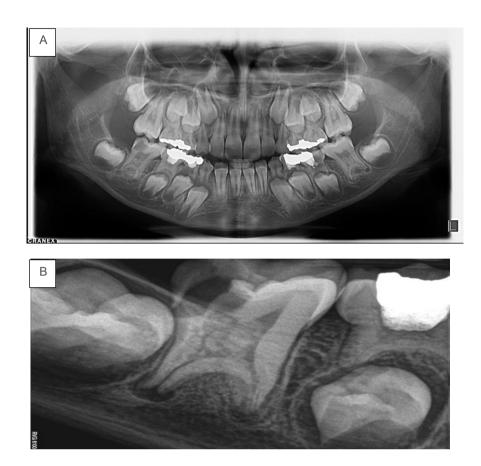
A) Panoramic view revealed an enlarged pulp chamber and pulp stones in bilateral molars, B) The intraoral radiograph shows deep occlusal caries, enlarged pulp chambers and apically shifted bifurcation and pulp stones, C) CBCT images cross-sectional view of Lower right molar
